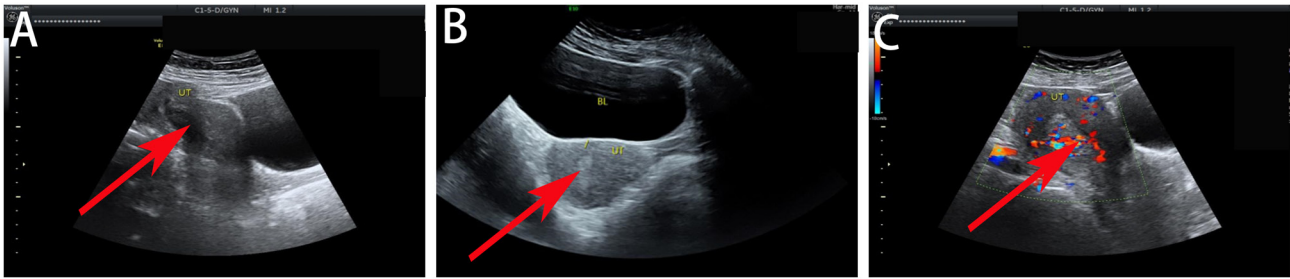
Misdiagnosis of embryonic arrest in three patients according to ultrasound (red arrow: Echo in the uterine cavity). (A) Case 1, (B) case 5 and (C) case 7.
